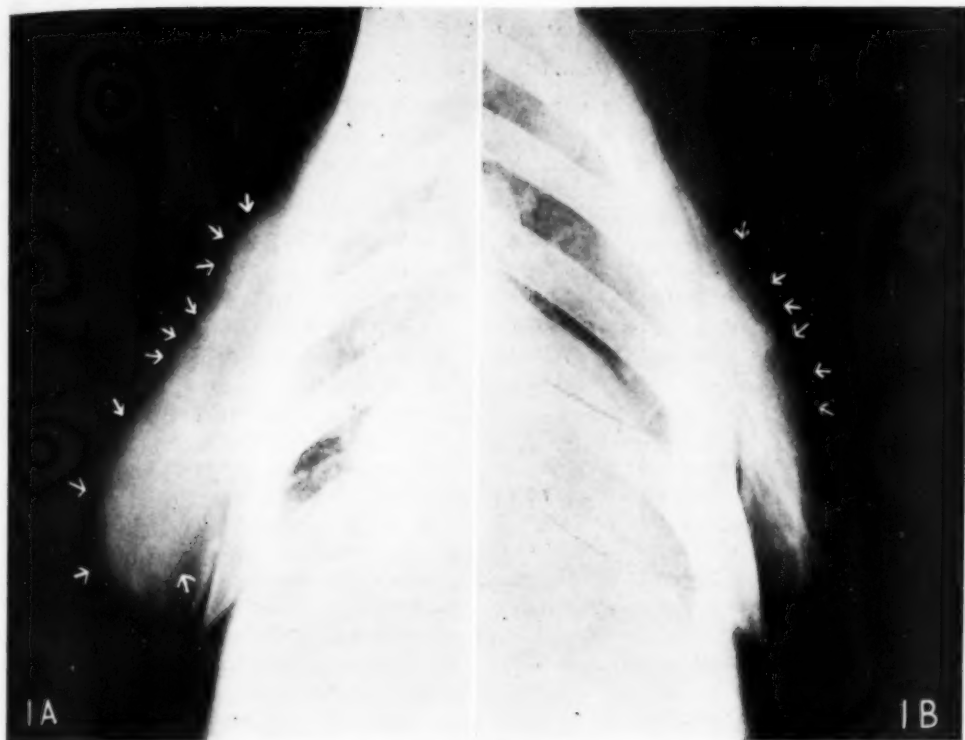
Roentgenogram of the right breast made with the patient standing in the right anterior oblique position. Note the dense mass which is infiltrating practically the entire breast and pectoral muscles.
